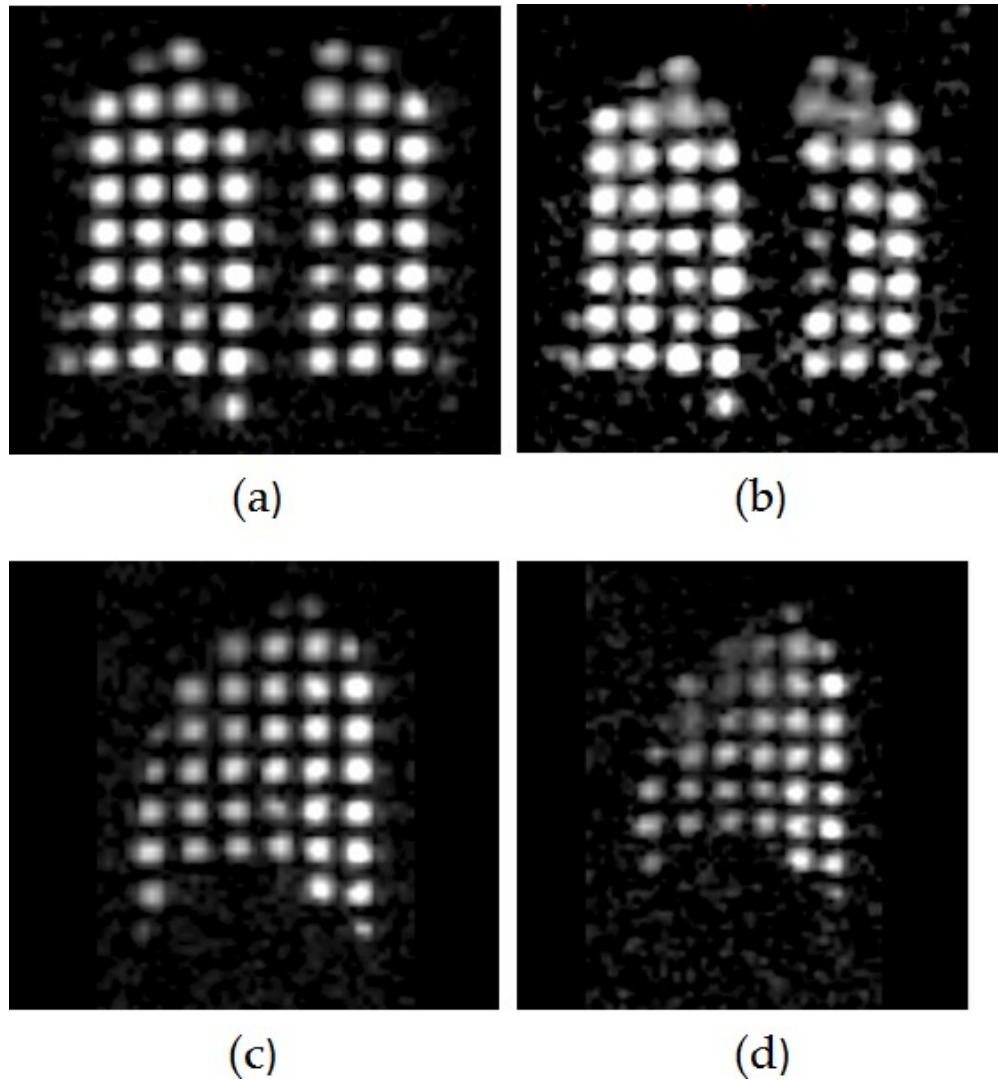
Examples of HP He-3 MR images in coronal view at (a) EOI and (b) EOE, and in the sagittal view t (c) EOI and (d) EOE.
